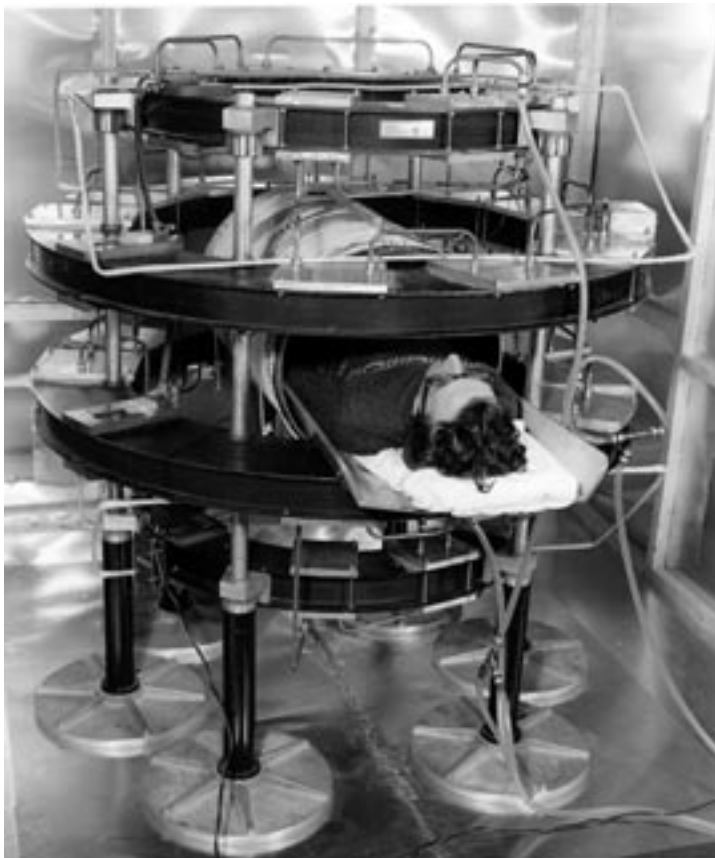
The first whole-body MRI of clinical usefulness (homemade) in the medical physics department, Aberdeen, c. 1980; Dr Hutchison is in the position of a patient.
